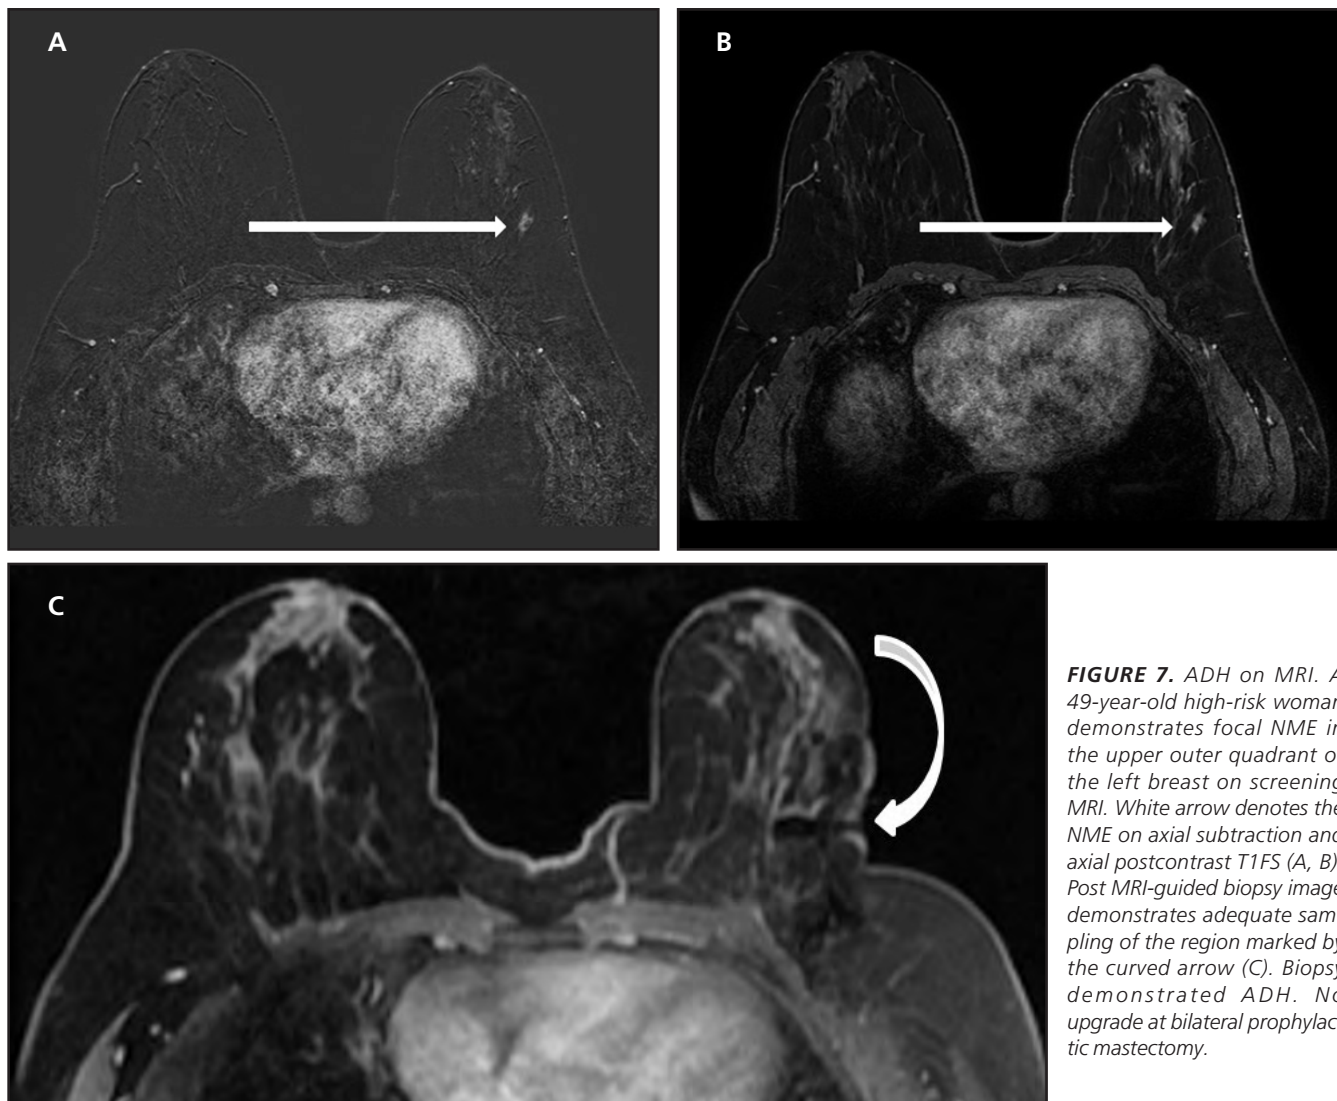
ADH on MRI. A 49-year-old high-risk woman demonstrates focal NME in the upper outer quadrant of the left breast on screening MRI. White arrow denotes the NME on axial subtraction and axial postcontrast T1FS (A, B). Post MRI-guided biopsy image demonstrates adequate sampling of the region marked by the curved arrow (C). Biopsy demonstrated ADH. No upgrade at bilateral prophylactic mastectomy.
